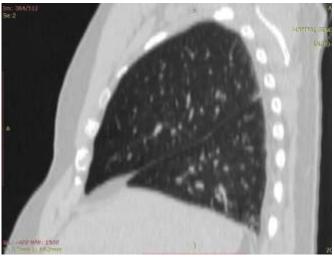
Chest CT in sagittal section, parenchymal window, showing 2 lung lobes on the left.
